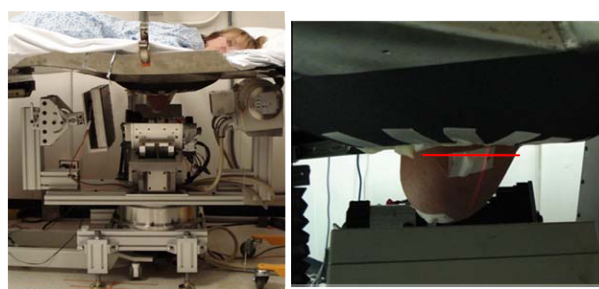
(Left) Images of a subject being scanned using the dual modality imaging system. This volunteer was scanned using a 360° trajectory with the x-ray tube shown passing underneath the subject's head. (Right) the red line on the pendant breast indicates the approximate depth of imaging into the breast using this imaging trajectory.
